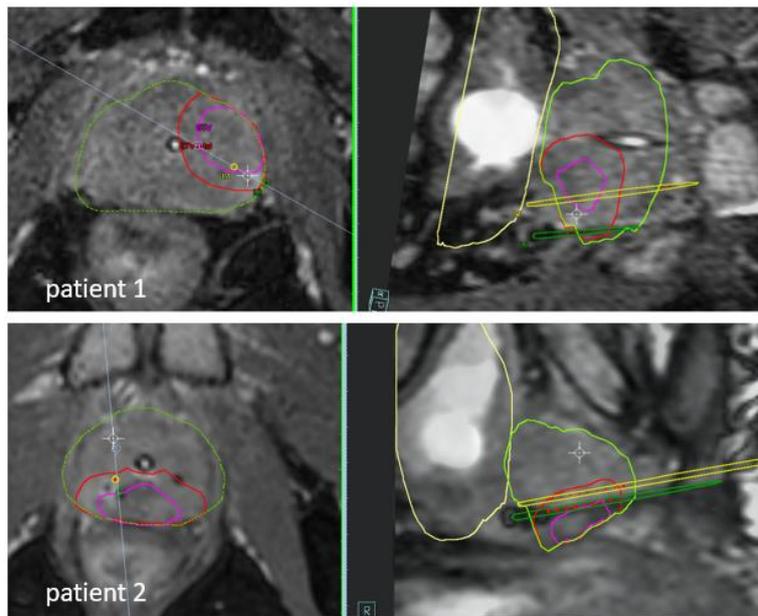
transversal and oblique MR images of the prostate with planned (yellow) and realized needle position (green), prostate (green), bladder (yellow), CTV (red) and GTV (purple); the white line in the transversal images depicts the oblique plane through the planned and realized needle.
